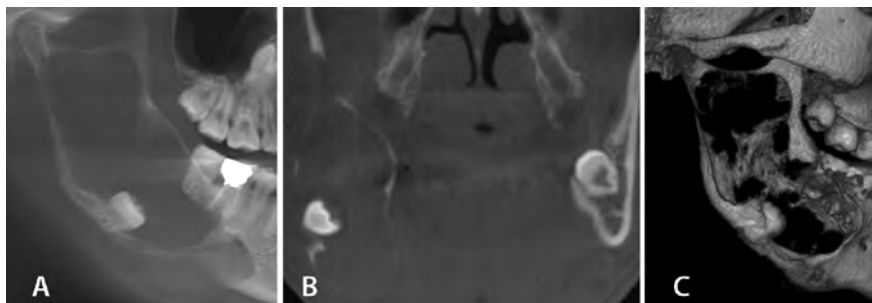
Ameloblastoma. An 18-year-old male. Data acquired using an iCAT CBCT machine. Images are reformatted in OnDemand 3-D, a third-party software. (A) Sagittal view of the right mandible showing a large multilocular lesion and inferior displacement of the third molar. (B) Coronal section through the angle of the mandible. Compared to the normal left side, the right side shows expansion in buccolingual aspect and lower border of the mandible. The third molar is next to the buccal cortical plate. (C) A 3-D reconstruction of the involved area, showing the thinning and perforation of the cortical plates. The superimposing structures (vertebra, hyoid bone) are subtracted by segmentation.
